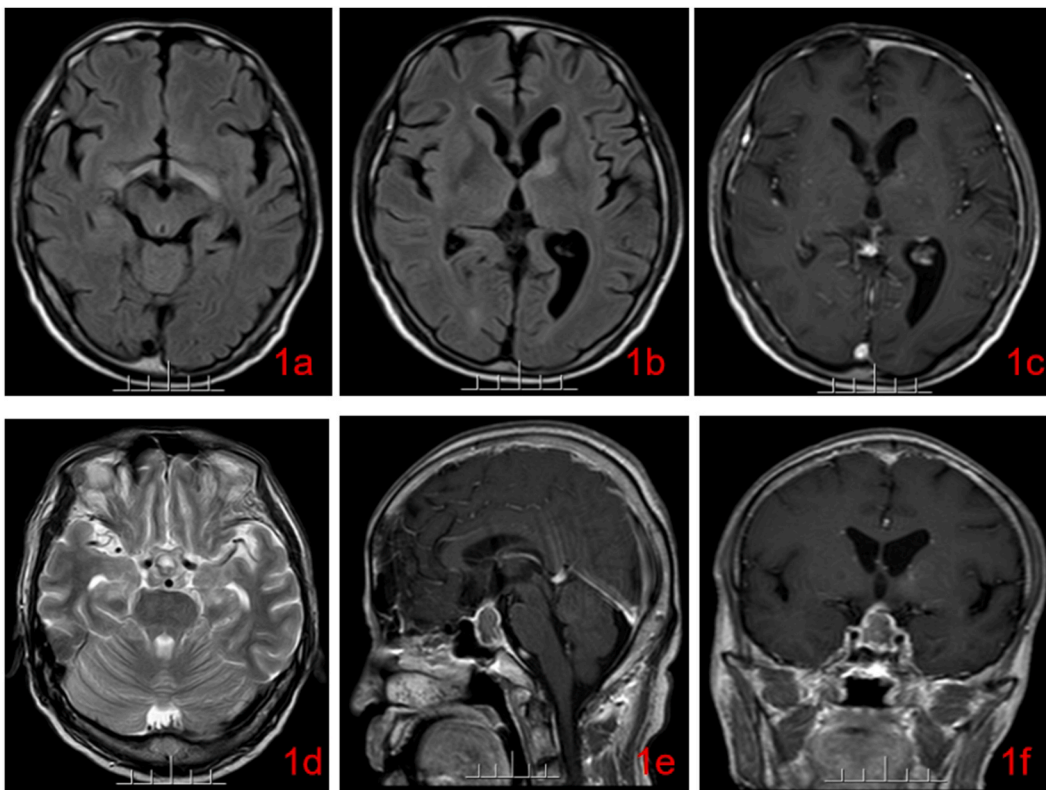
Brain magnetic resonance imaging (MRI) before treatment. Axial T2/fluid attenuated inversion recovery (FLAIR) showing hyperintensity of the optic tract, a low signal intensity inner and a high signal intensity outer of the left basal ganglia (1a, 1b). Enhanced axial T1W demonstrating multi-punctate and linear enhancements in the left basal ganglia and leptomeninges (1c). Axial T2W showing a circular asymmetry density in the sella turcica and suprasellar region (1d). Enhanced sagittal T1W and enhanced coronal T1W demonstrating a ring-like enhancement in the sella turcica and suprasellar region (1e, 1f).
